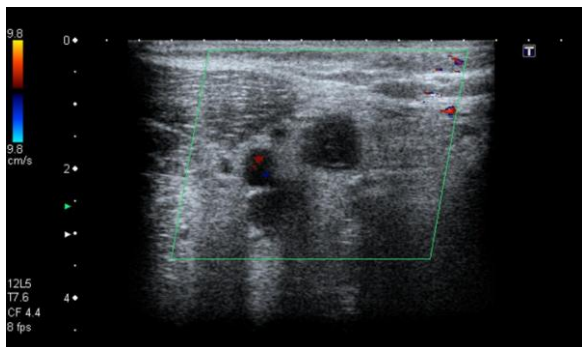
Doppler ultrasound showing left axillary vein thrombosis
